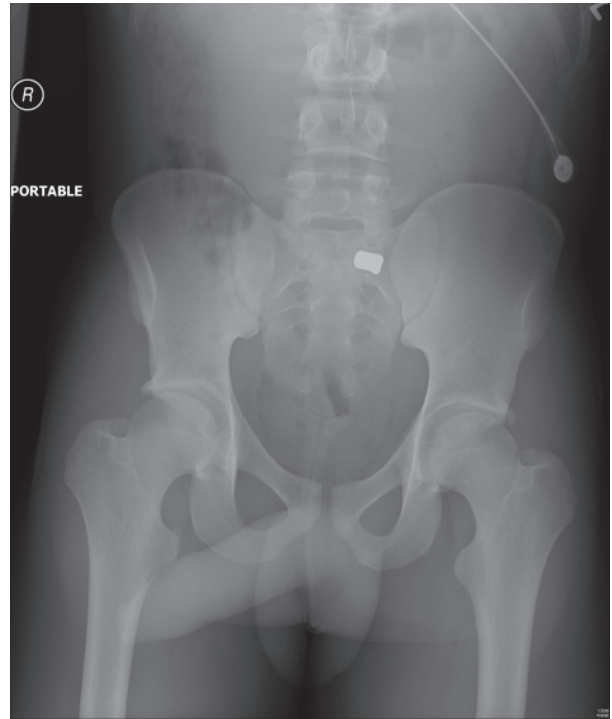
The portabile anteroposterior radiography of the pelvic in the emergency bay demonstrating the hyperdense object (bullet) in the pelvic cavity.
